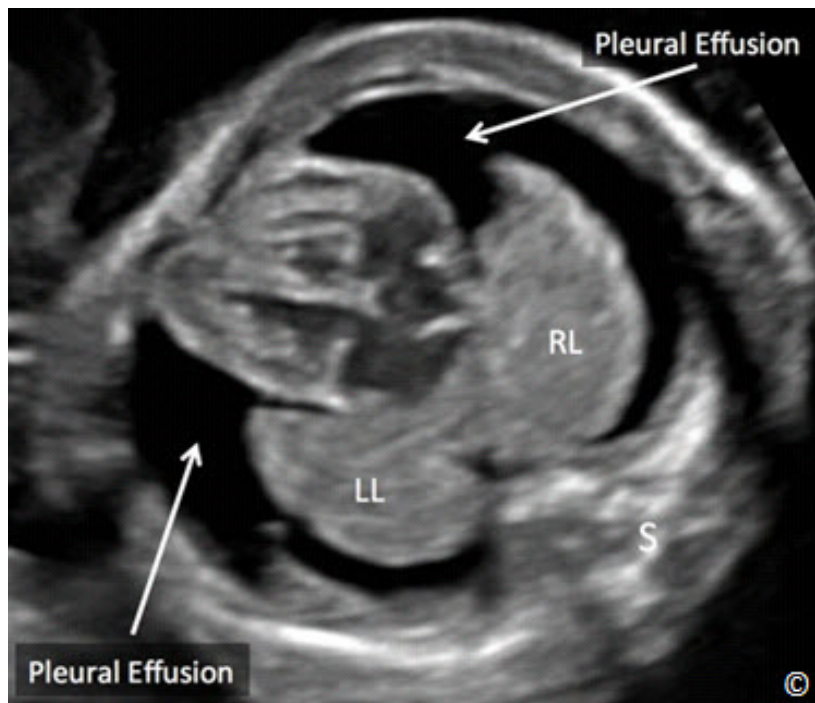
Transverse view of the fetal chest at 23 weeks' gestation showing bilateral pleural effusions (arrows). Pleural effusions regressed spontaneously and resolved in this fetus with follow-up ultrasound examinations. S = spine, RL = right lung, LL = left lung.
